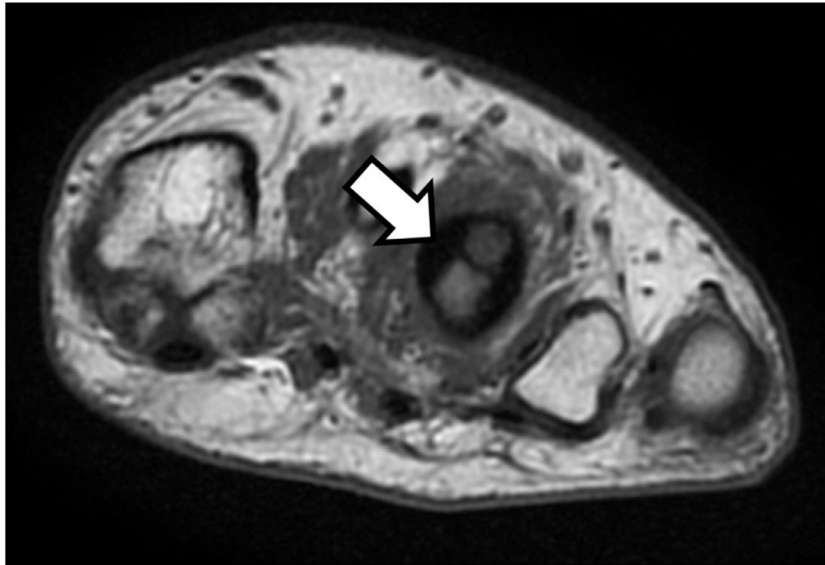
Coronal T1-weighted sequence of MRI scan of the left foot. OO is depicted as a target-like lesion (arrow) with a central hyperintense nidus surrounded by hypointense reactive sclerosis. Circumferential perilesional edema is also evident.
